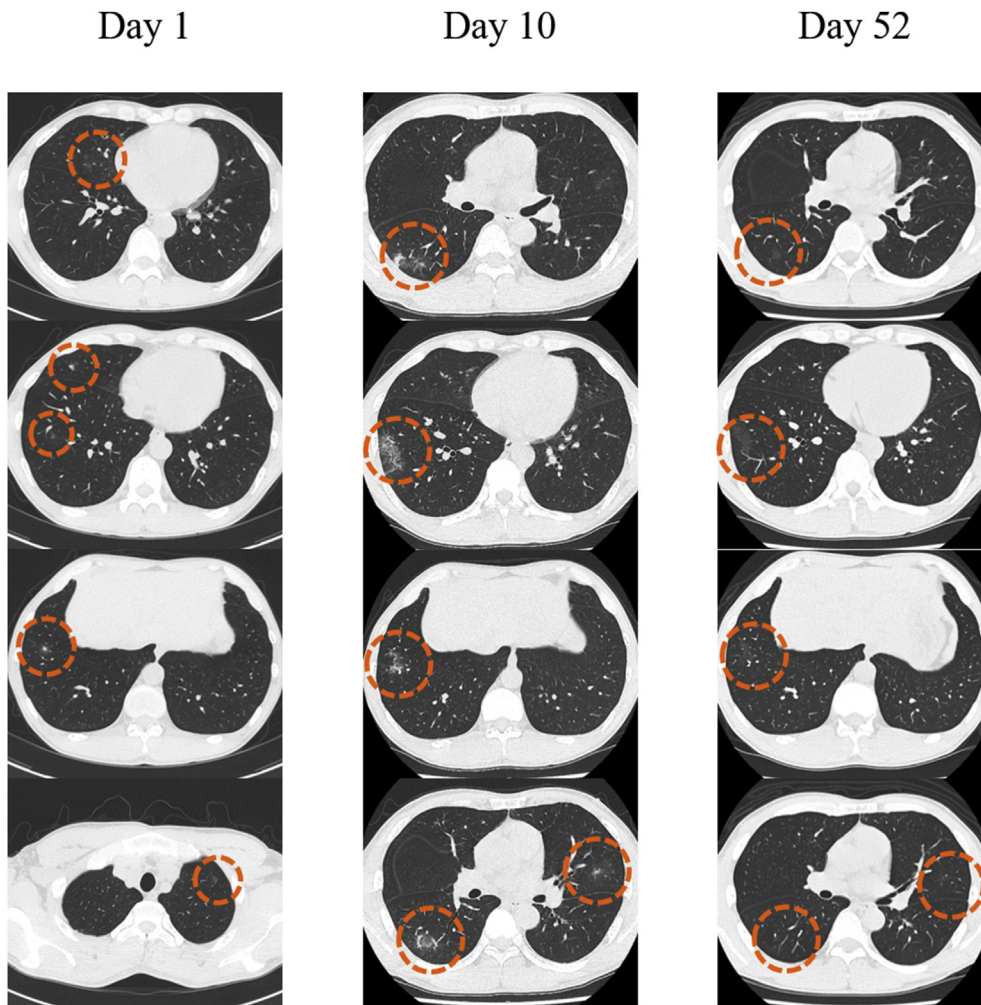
Clinical change in lung CT during COVID-19 treatment.
